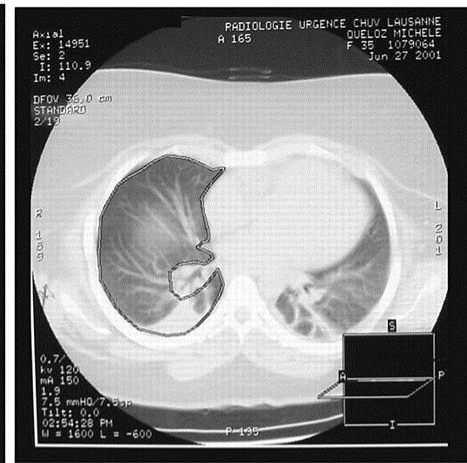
Samples of CT scans of a morbidly obese and a non-obese patient before anaesthesia, after extubation and 24 h later.
